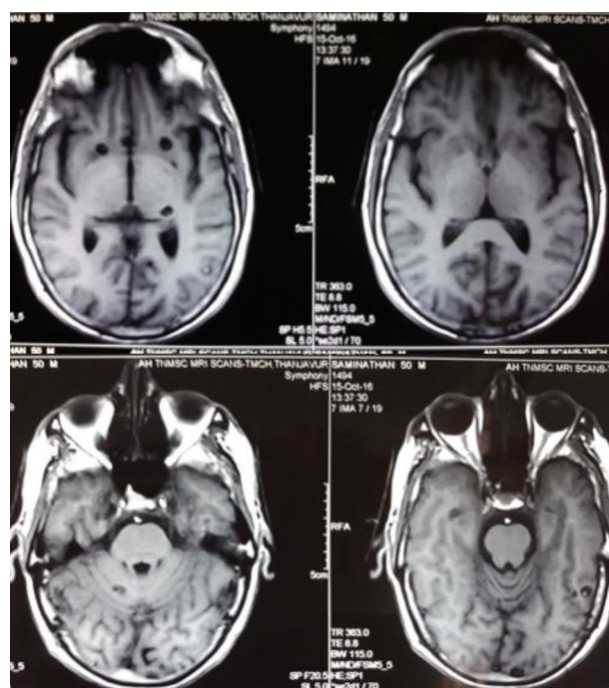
A 60 year old male patient presented to us with h/o 3 episodes of generalised tonic clonic seizures along with uprolling of eyeballs. On neuroimaging multiple characteristic cystic lesions were found in brain parenchyma and brain stem. However there was no mass effect or hydrocephalus seen on neuroimaging. The characteristic finding on MRI include cysts lesions which on T1 appear hypo intense and on T2 weighted images there is a low ring signal surrounded by hyper intense lesion due to edema
